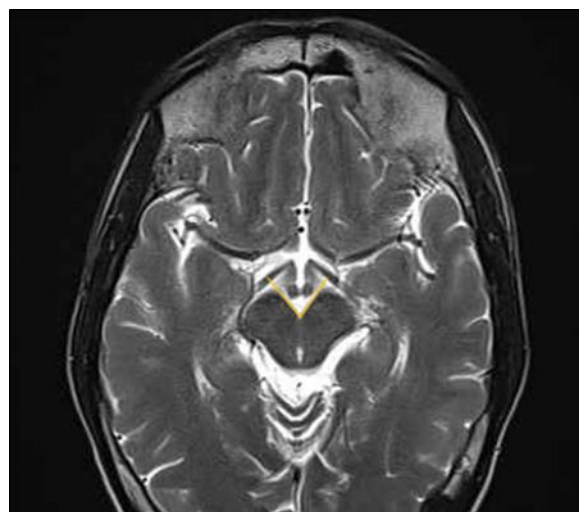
T2 axial section MRI Brain showing interpeduncular angle measurement at the level of the mamillary body
